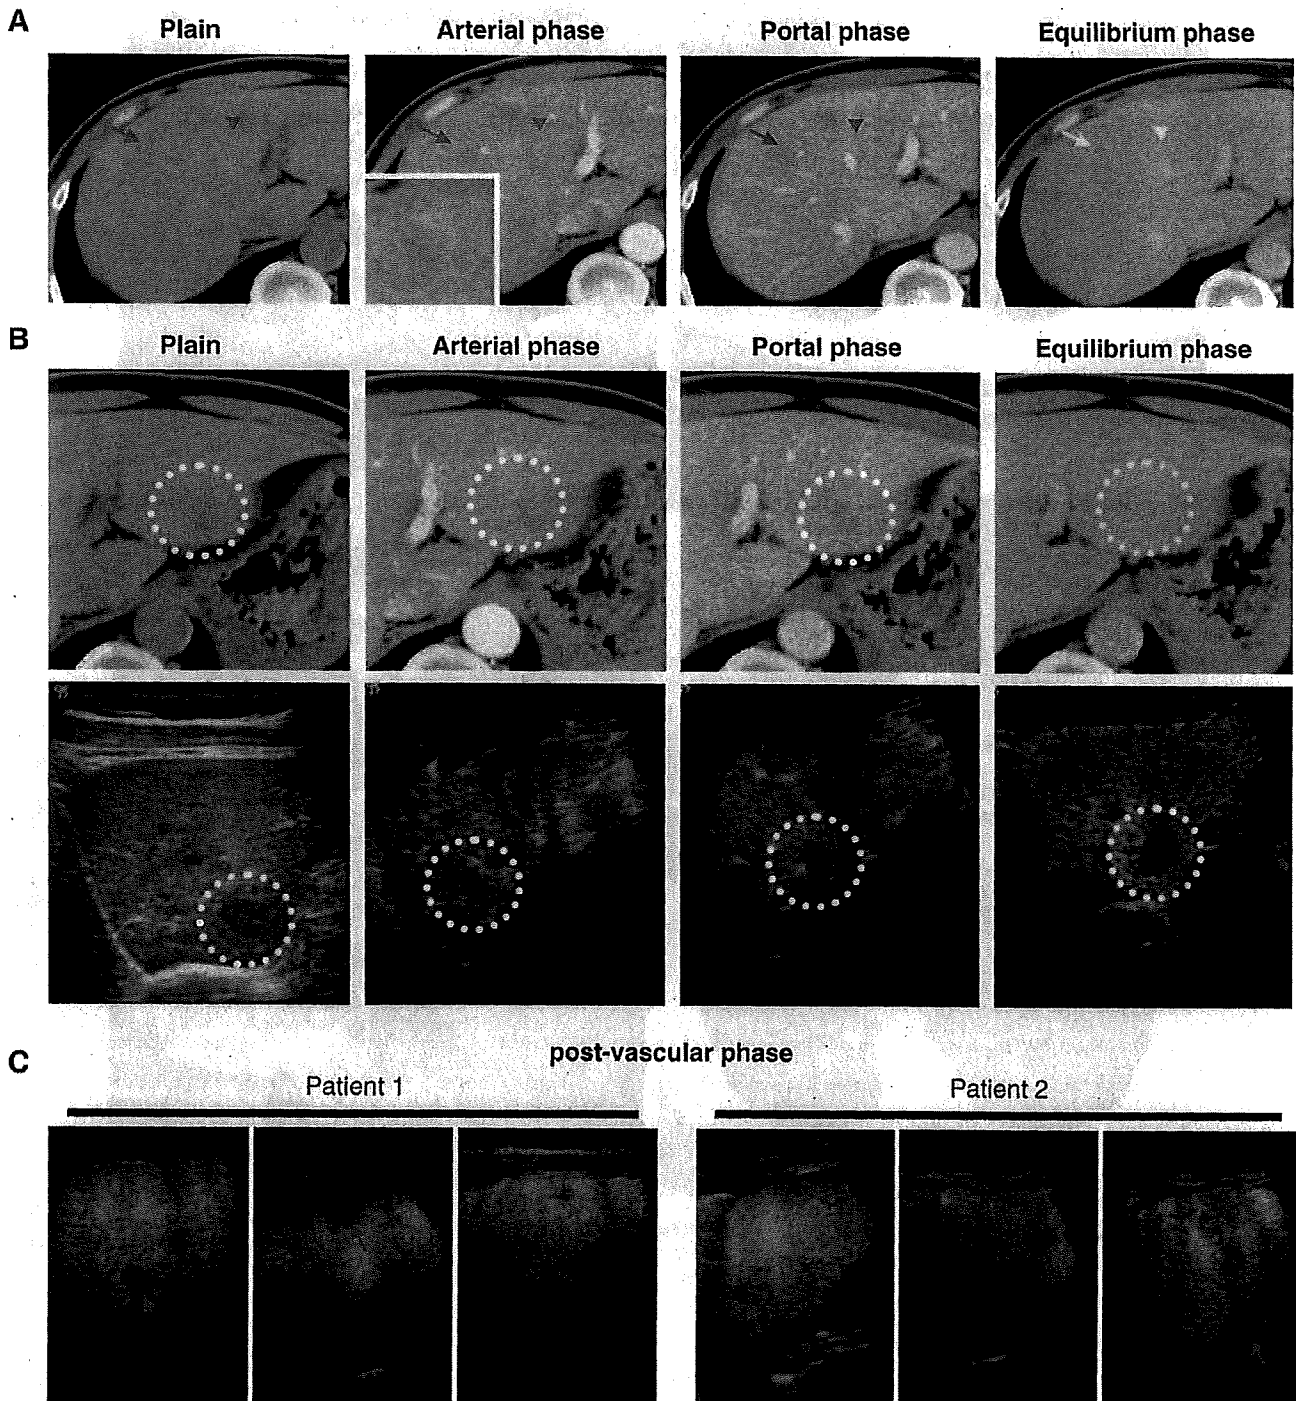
CT and US images of hepatic lesions. A. Two nodules (arrow and arrowhead) in the liver of Patient 1 are shown. That shown by the arrowhead (magnified in inset) had weak peripheral rim enhancement in the arterial phase, while both were undetectable in the equilibrium phase. B. A lesion (circle with broken line) in the left lobe of Patient 1 was targeted with Sonazoid-contrast US (lower) and the results were compared with contrast CT images (upper). With CT, the lesion was best seen in the portal phase and became undetectable in the equilibrium phase, while it was clearly shown as an un-enhanced area in the equilibrium phase. C. Post-vascular Sonazoid-contrast US images revealed that the lesions (arrows) remained hypoechoic. Three lesions each from Patients 1 and 2 are shown.
